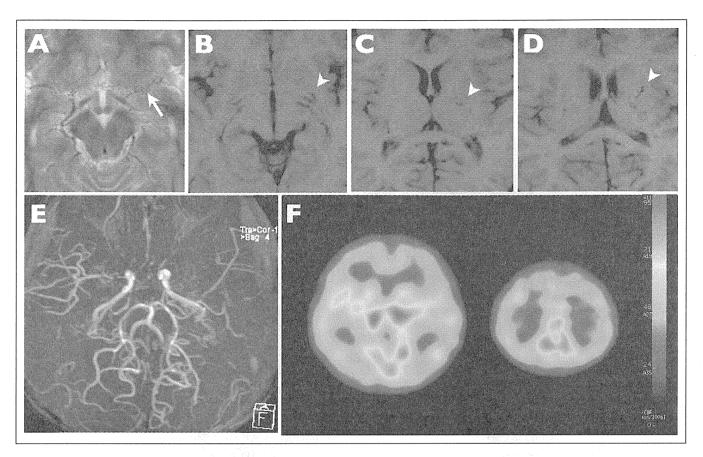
Radiologic findings of the 6-year-old boy with moyamoya disease at admission. A, T2-weighted MRI shows occlusive changes of the horizontal portion of the left middle cerebral artery and fine vascular network around it (arrow). B-D, T1-weighted MRI demonstrates the dilated basal moyamoya vessels in the bilateral basal ganglia. The finding is more prominent in the left side (arrow heads). E, Magnetic resonance angiography reveals the occlusive changes in the bilateral carotid forks. The finding is more prominent in the left side, and the flow signals of the distal branches of the left middle cerebral artery are markedly reduced. F, N-isopropyl-p-[123I]iodoamphetamine single-photon emission computed tomography (SPECT) demonstrates a marked decrease of cerebral blood flow in the territory of the bilateral internal carotid arteries.
